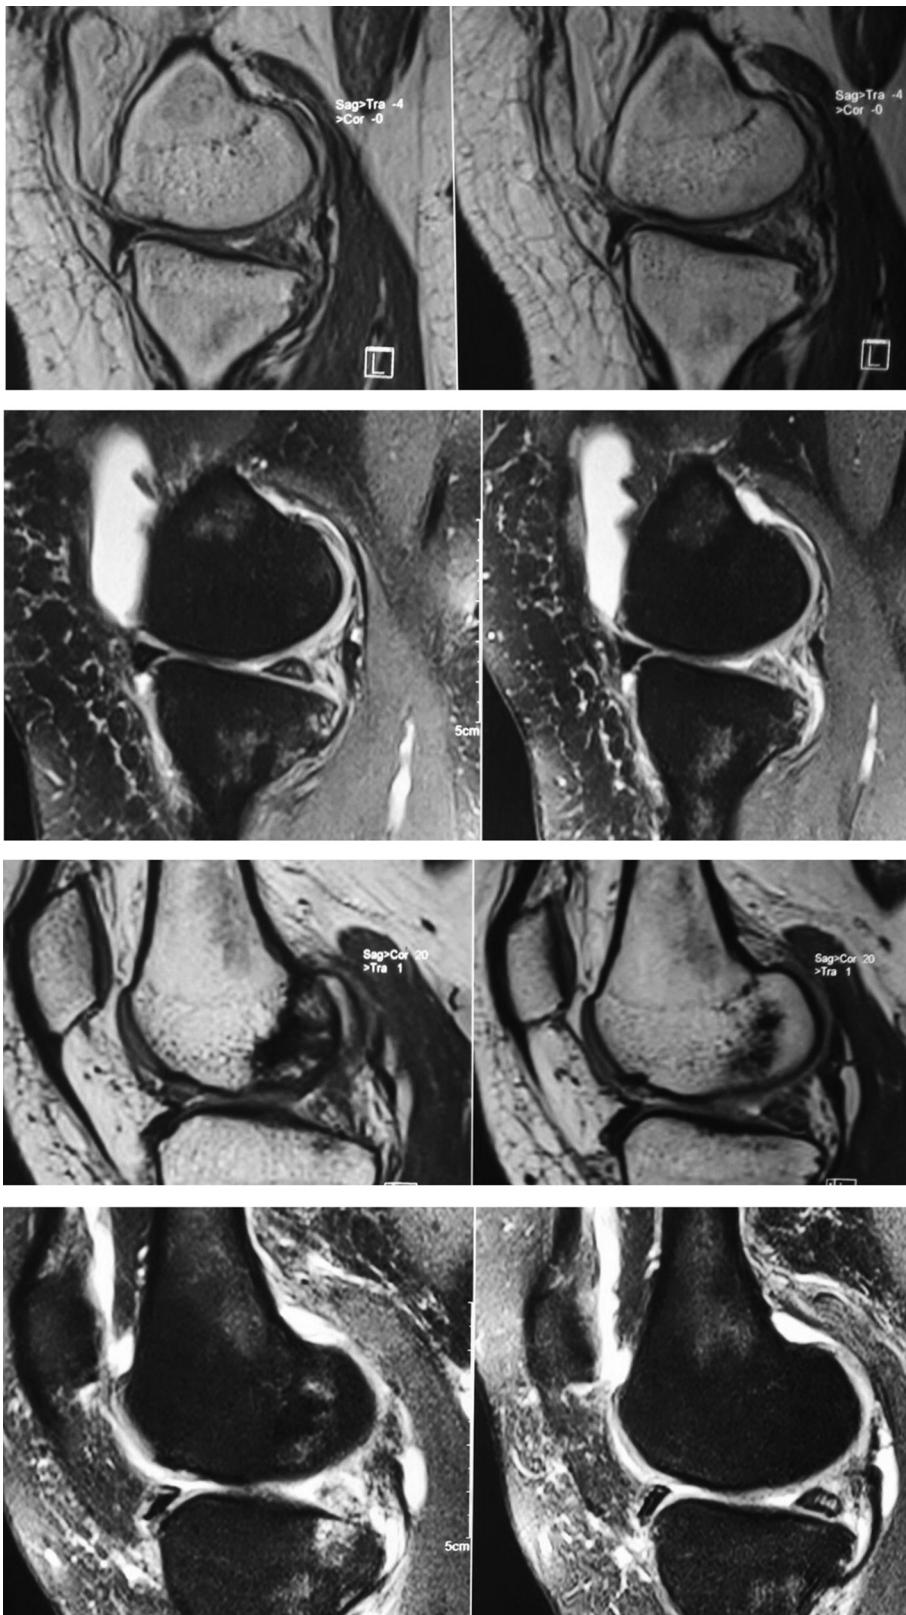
Pre-operative MRI (T1 and STIR images) of the left and right knees showing bilateral posterior meniscal root tears with medial meniscal extrusion (translation values given on MR).
